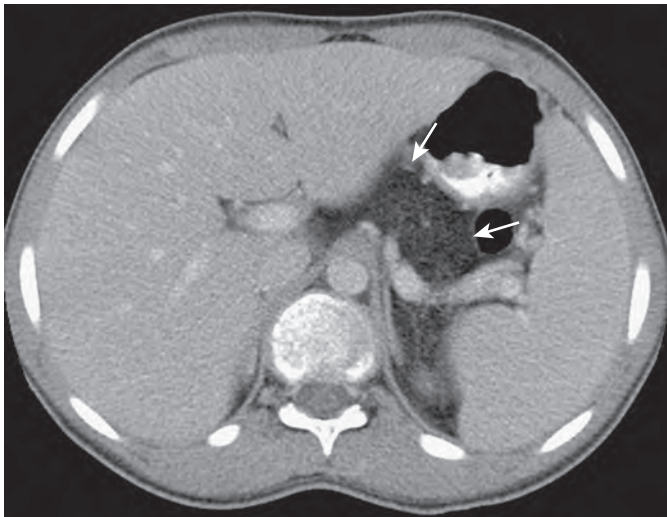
Shwachman-Diamond syndrome. CT shows the loss of pancreatic parenchyma from atrophy and infiltration of the pancreas by fat (arrows) in a young boy with Shwachman-Diamond syndrome.
